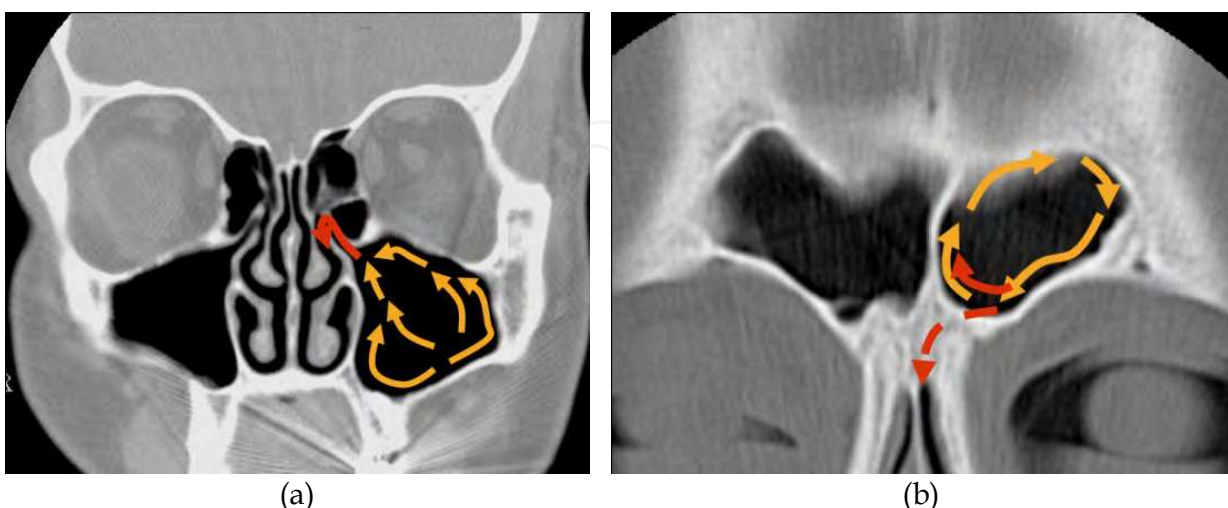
Coronal CT demonstrating the mucociliary drainage route for (a) the maxillary sinus with it's final route through the ethmoid infundibulum (red arrow) and (b) the frontal sinus with it's final route through the frontal recess (red dotted arrow).
